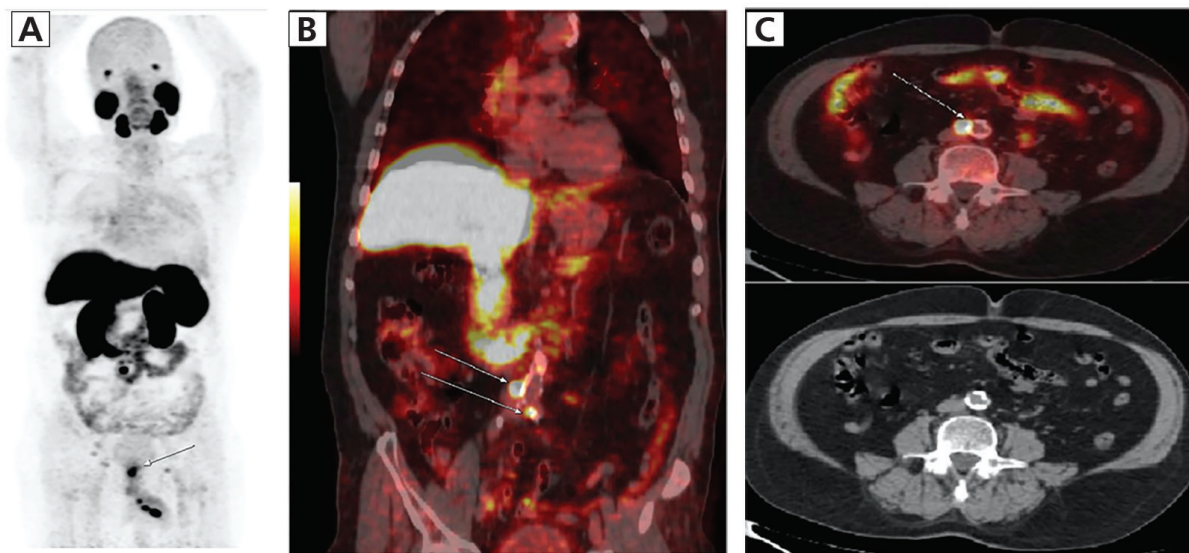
(A) Maximum intensity projection (MIP) of ^{18}F -prostate-specific membrane antigen (PSMA) 1007 positron emission tomography/computed tomography (PET/CT) showing significant uptake at the prostate apex [maximum standardized uptake value (SUV_{max})=12.9], indicating local recurrence (Figure 1). Noted: several hypermetabolic foci in the abdominopelvic region (SUV_{max} =3.3-19.5 arrows). (B) Fusion image in coronal section showing multiple hypermetabolic foci in the abdominopelvic region (SUV_{max} =3.3-19.5 arrows). These uptakes were attributed to active aortic calcifications. (C) Fusion image in axial section showing a hypermetabolic focus in the lombo-aortic bifurcation (SUV_{max} =19.5 arrow). This uptake was also attributed to active aortic calcification. Noted: CT image in axial section showing no suspicious lymphadenopathy.
